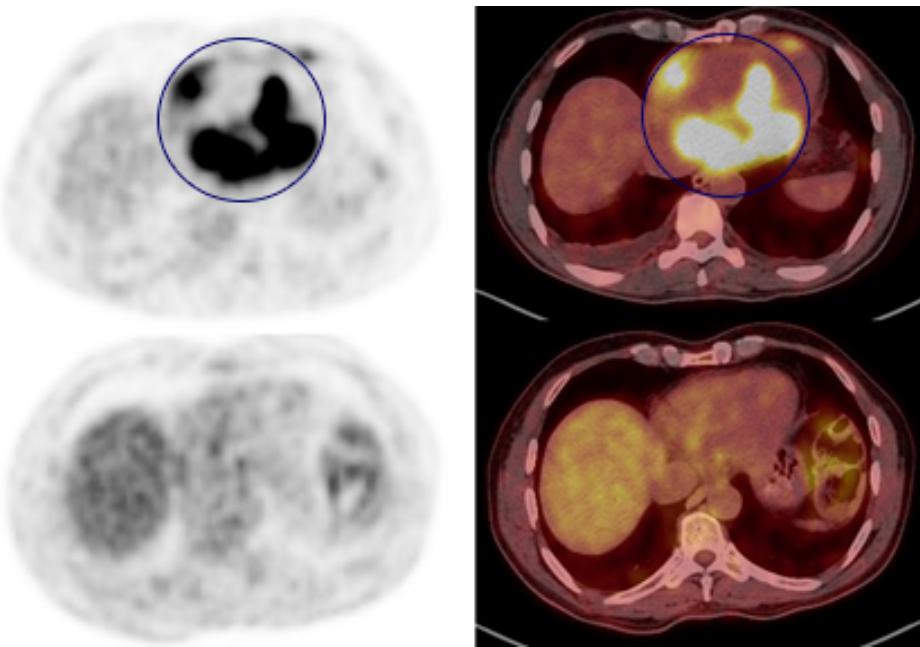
F18-FDG PET/CT axial images. follow-up scan after three cycles of chemotherapy demonstrating complete metabolic response.
